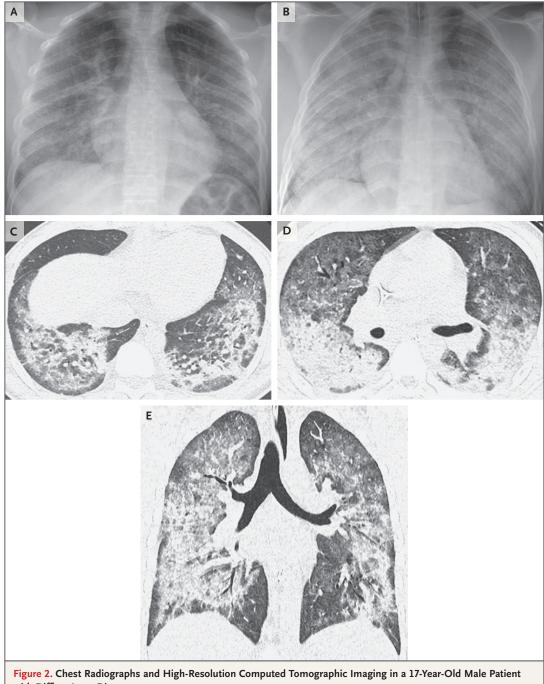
Chest Radiographs and High-Resolution Computed Tomographic Imaging in a 17-Year-Old Male Patient with Diffuse Lung Disease.
